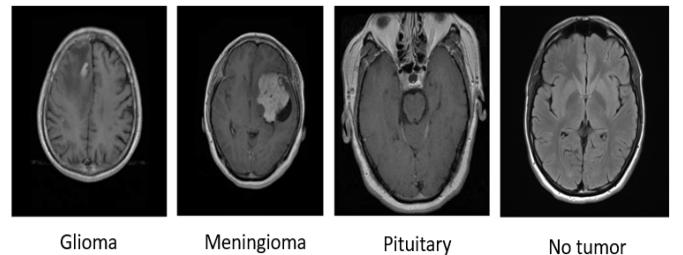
Dataset samples showing four brain MRI classes
